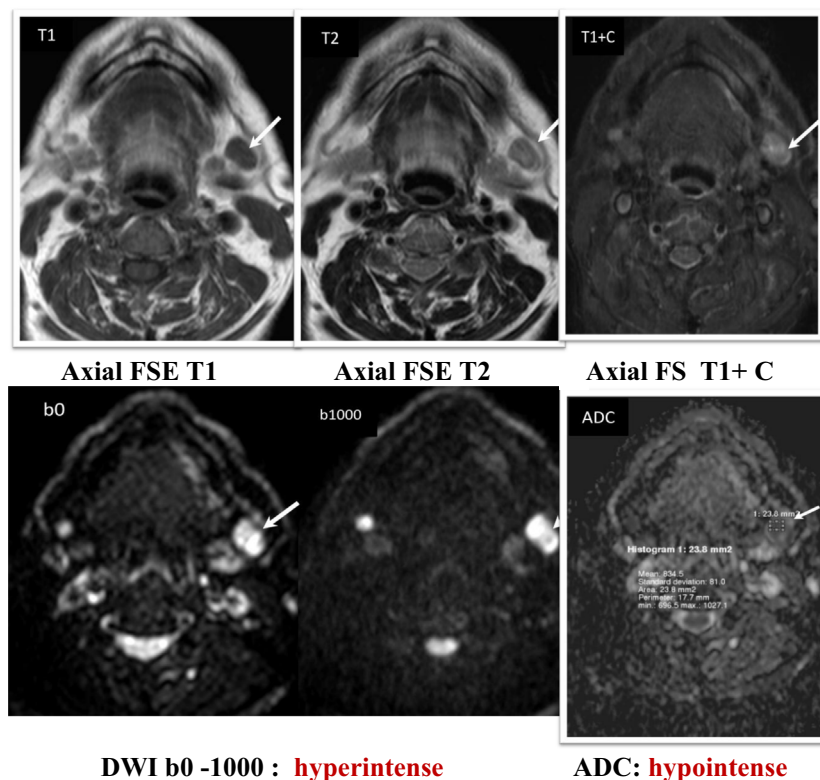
A 55 year old male presenting with left sided retromolar malignant mass of insidious onset. MRI neck was done for staging.
